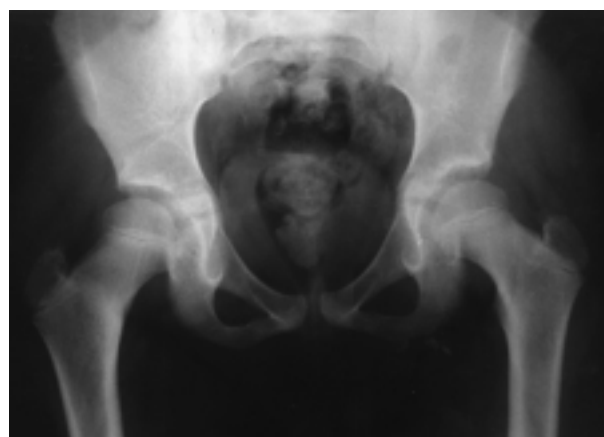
5-month radiographic follow-up showing the healing of the fracture.
